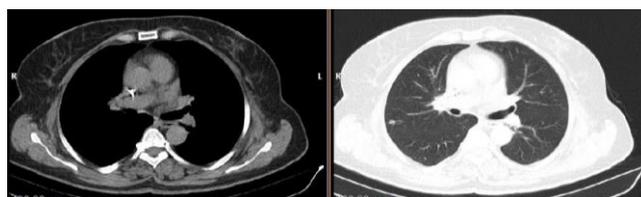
Thoracic CT scan showing nodule in right hemithorax
